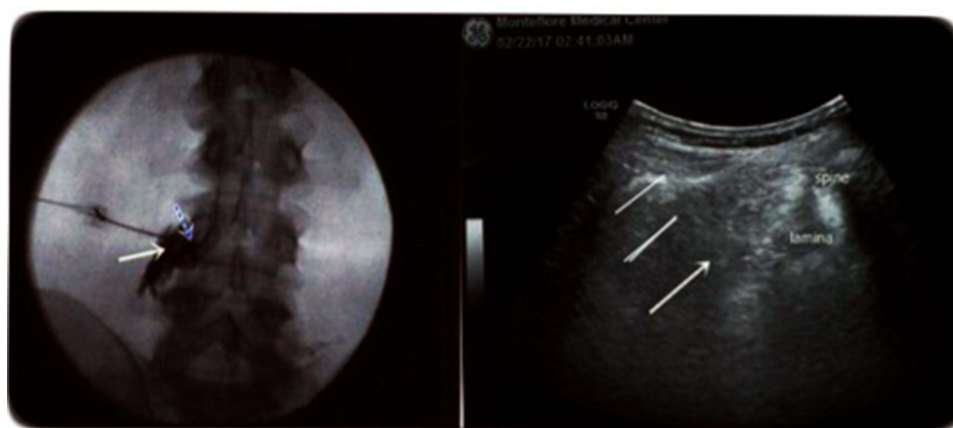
L3 transforaminal epidural injection. This demonstrates needle shadow (arrows) in ultrasound view (right) and corresponding contrast fluoroscopic confirmation of epidural spread (left).
